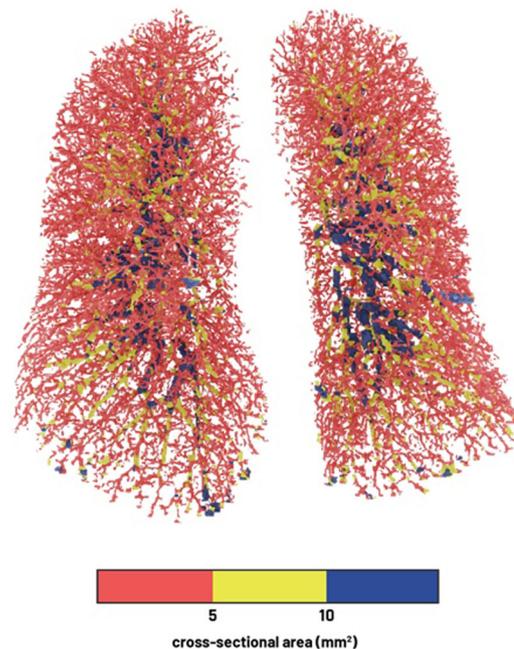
Vascular tree, color-coded by vessel cross-sectional area, for example, healthy volunteer adapted from Lins et al. Quantitative computed tomography (qCT)-derived volume of pulmonary vessels < 5 mm² in cross-sectional area denotes the cumulative volume of red vessels, qCT-derived volume of pulmonary vessels between 5 and 10 mm² in cross-sectional area yellow vessels, and qCT-derived volume of pulmonary vessels > 10 mm² in cross-sectional area blue vessels.
